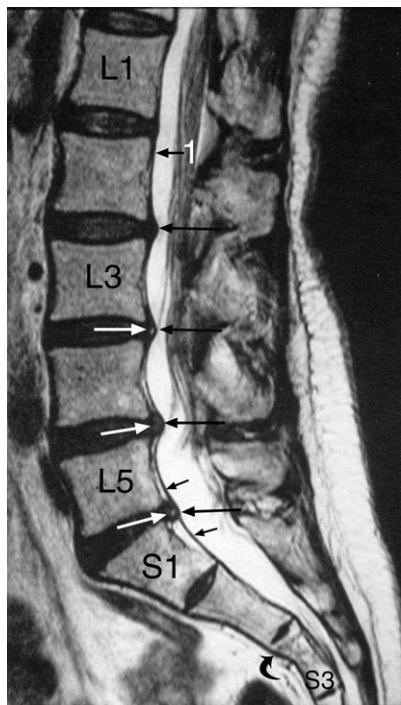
Lumbar spine MRI sagittal T2-weighted image showing desiccation of the lumbar discs, increasing caudally. 1 = posterior longitudinal ligament. There is mild bulging of the annulus at each level from L2 to S1 (long black arrows). There is a posterior mid-line annular tear at L3–4, L4–5 and L5–S1 seen as a high intensity zone (white arrows). The anterior surface of the dural tube is indicated by short black arrows. Note the line through the upper one-third portion of the third sacral segment (S3) (curved black arrow).
